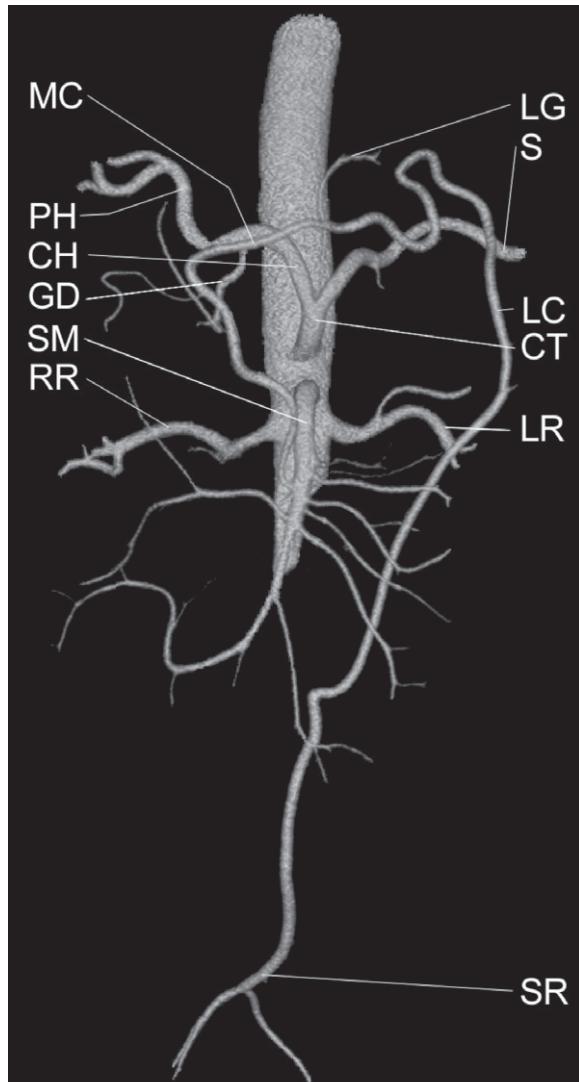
Volume rendering, anterior view. Visceral branches of abdominal aorta: CT – celiac trunk, CH – common hepatic, GD – gastroduodenal, PH – proper hepatic, S – splenic, SM – superior mesenteric, MC – middle colic, LC – left colic, RR – right renal, LR – left renal, SR – superior rectal.
